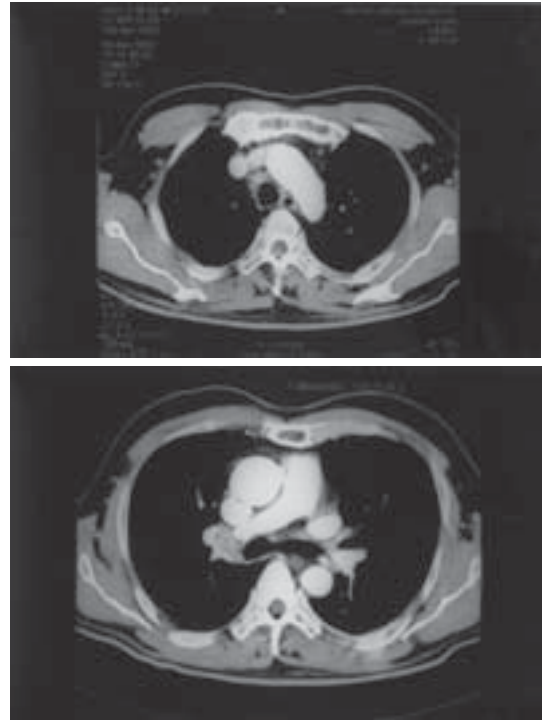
Repeated CT chest scan after complete treatment revealed no right tracheobronchial mass and only small right paratracheal nodes.
